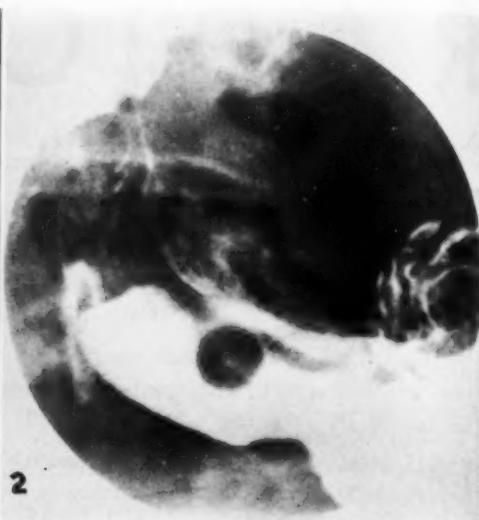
Case II. Roentgenogram of the barium-filled stomach made with compression under the fluoroscope. A sharp rounded filling defect in the antrum is observed. Within it can be seen a small fleck of barium representing the ulceration on its surface. Note the fold of mucous membrane lying just above the granuloma.
